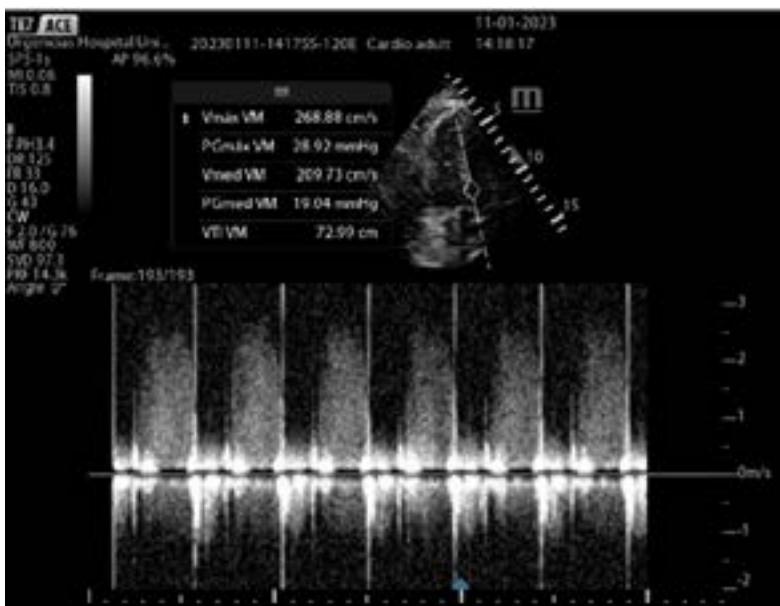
Point-of-care focused cardiac ultrasound showing prosthetic valve stenosis due to altered mean gradient.
